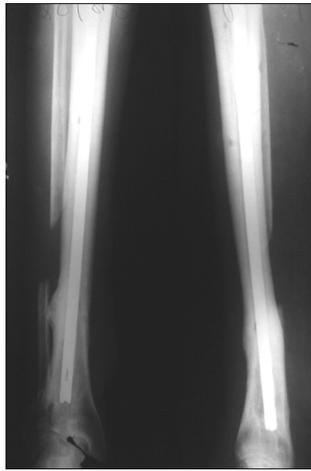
24 weeks post-operative X-ray tibia
